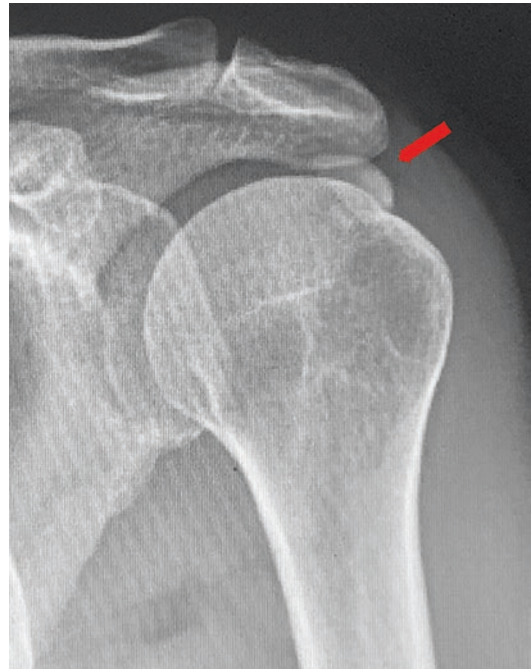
Anteroposterior radiograph showing calcific tendinitis (arrow)
